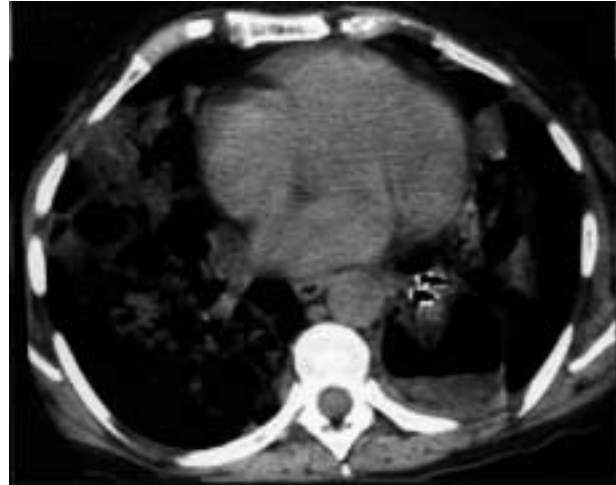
Multiple bilateral cavities on the computed tomographic (CT) scan with an air fluid level in the left lower lobe.
